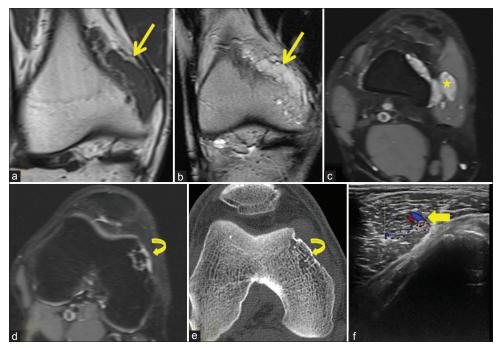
Magnetic resonance imaging, computed tomography, and ultrasonography screening, (a) coronal magnetic resonance imaging shows a well-defined lobulated lesion isointense to muscle in T1-weighted image (arrow in a), (b) heterogeneously hyperintense on T2-weighted images (arrow in b) along the medial femoral condyle which is extending to involve the medial vastus muscle as seen in fat-saturated T2-weighted axial image (asterix in c), (d and e) there is also a small intraosseous component in the adjacent medial condyle which is seen as widened intertrabecular spaces and thickened adjacent trabeculae as seen in axial fat-saturated T2-weighted image and axial computed tomography images (curved arrow in d and e), (f) ultrasonography screening showed slow-flow vascular channels within it (arrowhead in f)
